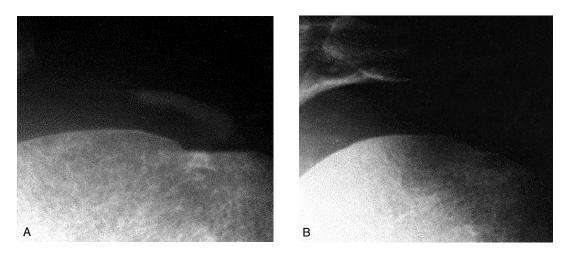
(A) Anteroposterior radiograph showing a Gärtner I calcium deposit (homogenous structure with well defined borders). (B) Anteroposterior radiograph showing complete disintegration 12 months after shock wave application.
